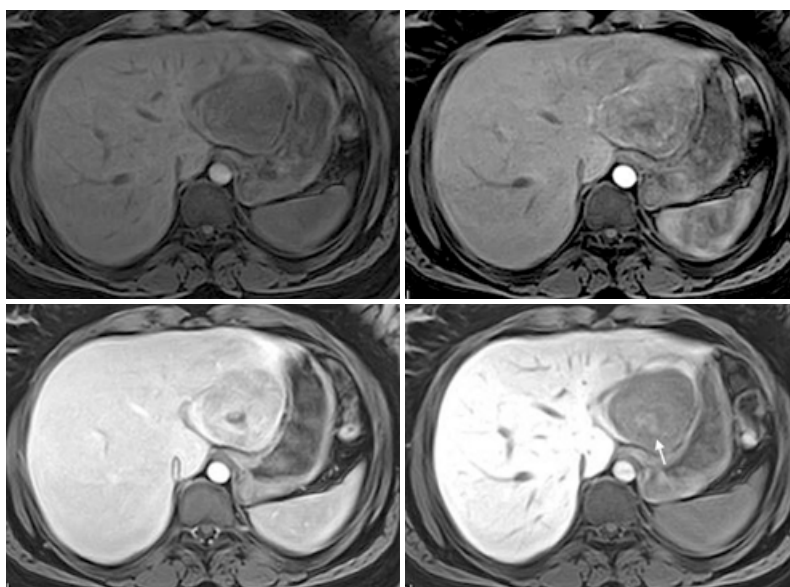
MR images of abdominal organs (T1 WI axial images): a – before contrast enhancement, b – post-contrast enhancement, hepatic arterial phase, c – parenchymal phase, d – delayed phase (central part of the tumour shows hyperintense signal - arrowed).
